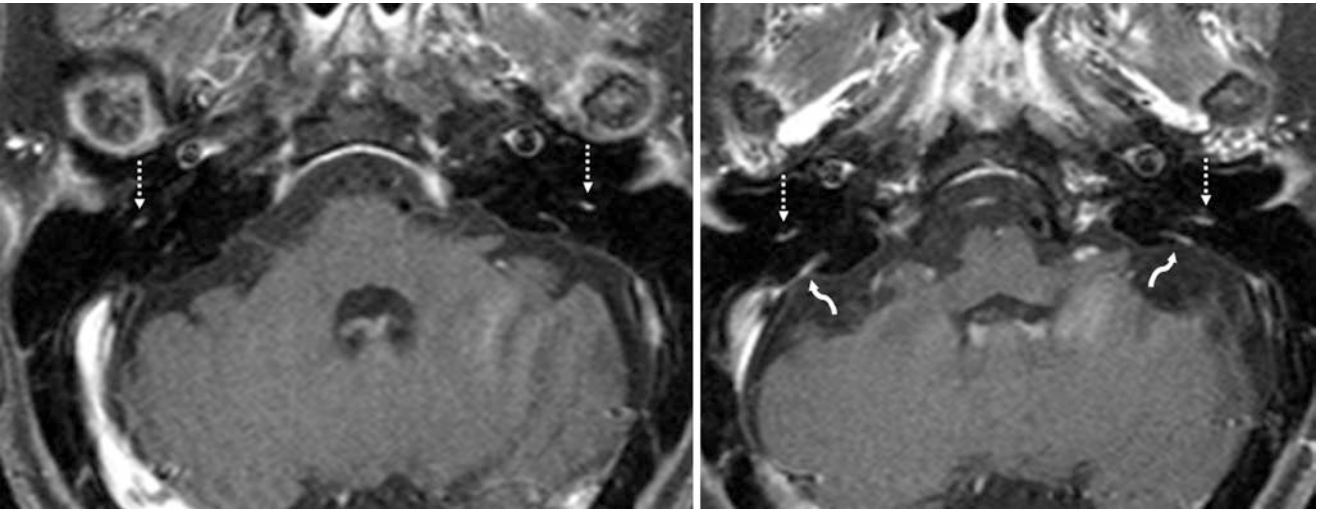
A 55-year-old patient with a 1.5 T MRI for *chronic* hearing loss. There is normal bilateral enhancement of the descending (mastoid) segments of CN7 (*dotted arrows*). Also, note enhancement of both
